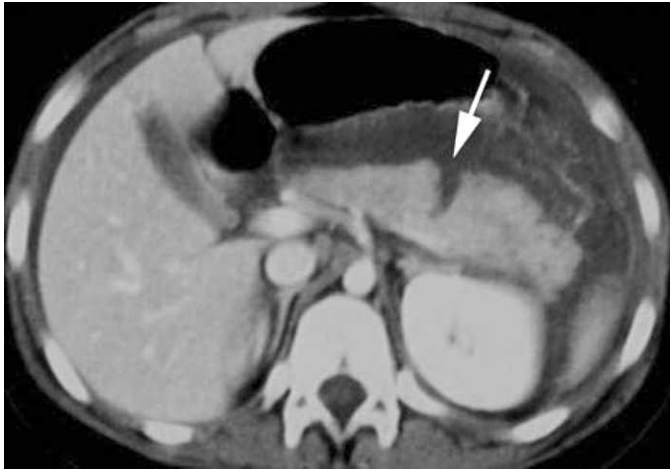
Computed tomography scan showing complete transection of the pancreas at the junction of the head and neck and fluid tracking adjacent to the pancreas. The latter likely represents secreted pancreatic enzymes from the injury. This image is not of our patient but is from Gupta A, Stuhfaut JW, Fleming KW, Lucey BC, Soto JAT. Blunt trauma of the pancreas and biliary tract: a multimodality imaging approach to diagnosis. *Radiographics*. 2004;24(5):1381–1395.¹⁸ Reprinted by permission of the Radiological Society of North America.
